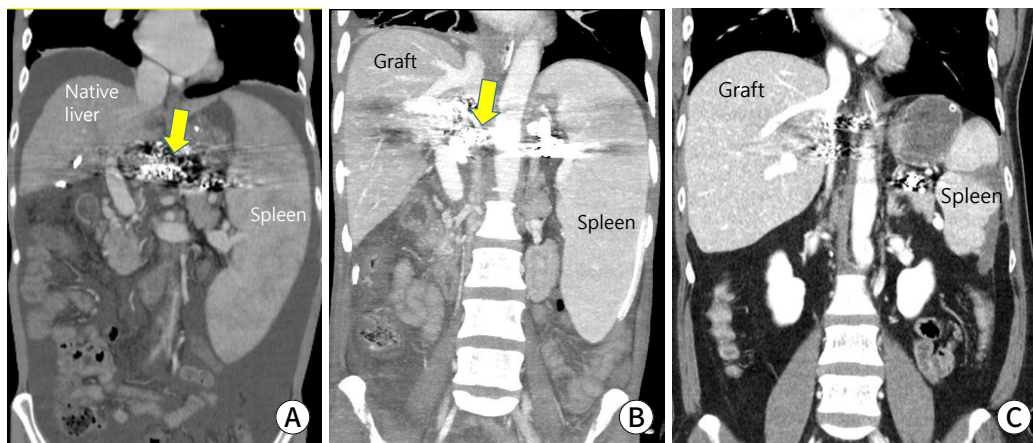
Post-transplant splenic arterial embolization to reduce portal hypertension. A 40-yr-old woman with hepatitis B-related liver cirrhosis with the hepatorenal syndrome and uncontrolled ascites underwent living-donor liver transplantation from his 35-yr-old wife using a right liver graft. He underwent gastorenal shunt occlusion before transplantation to control variceal bleeding and encephalopathy. One mo after transplantation, the patient underwent partial occlusion of the splenic artery because of uncontrolled ascites related to small-for-size syndrome (arrow, material for gastorenal shunt occlusion). (A) A preoperative recipient computed tomography (CT) scan. (B) A CT scan of postoperative day 7. (C) A CT scan 2 yrs after transplantation.
